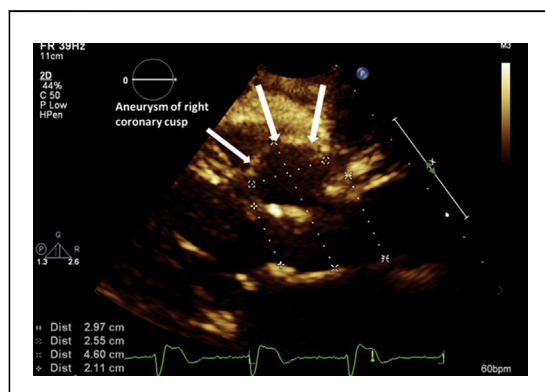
Transthoracic Echocardiogram Parasternal Long-Axis View
